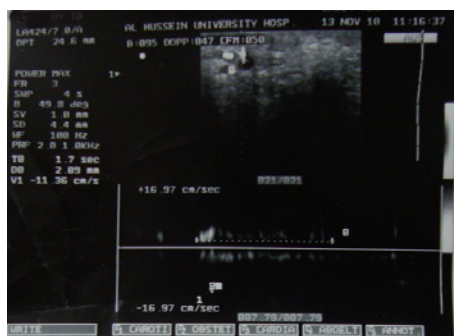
Duplex Ultrasonographic study(Largest vein diameter 2 mm with reflux time 1.7 sec) of patient number 5.
